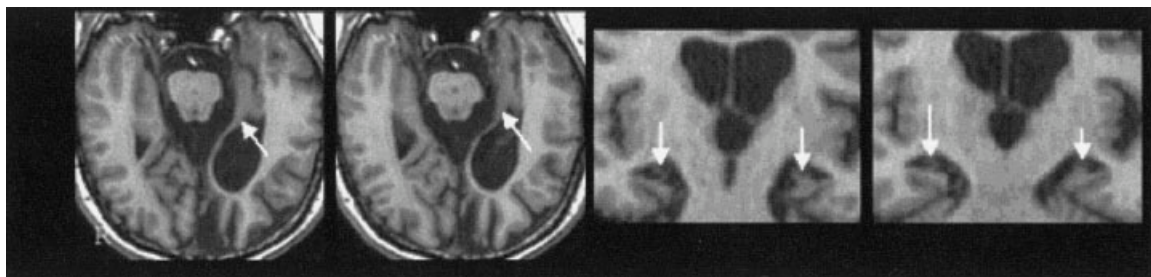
Patient K.C.'s MRI displaying the extensive damage to the hippocampi and extra-hippocampal MTL cortices bilaterally.
